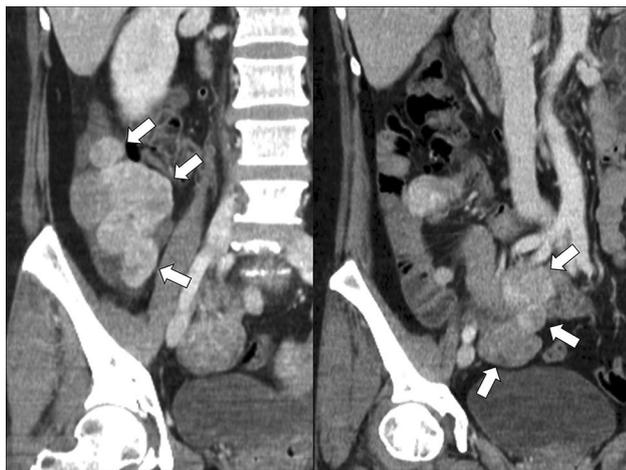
A 47-year-old woman with NF1. Enhanced CT coronal images show multiple, variable-sized, enhanced masses in the small bowel (arrows). Six high-risk GISTs were confirmed in the jejunum. [Reprinted from *Clinical Radiology*, 71(2), Kim SW et al., *Gastrointestinal stromal tumours (GISTs) with a thousand faces: atypical manifestations and causes of misdiagnosis on imaging*, e140, 2016, with permission from Elsevier]
